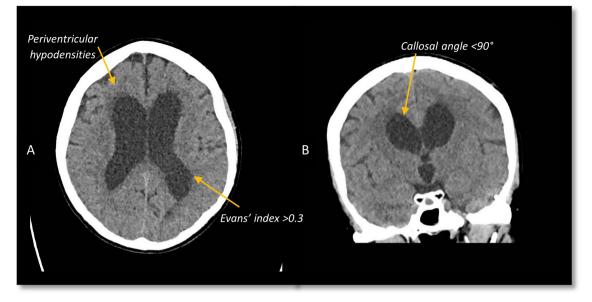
CT scan of head showing hydrocephalus with NPH features. NPH, normal pressure hydrocephalus.
